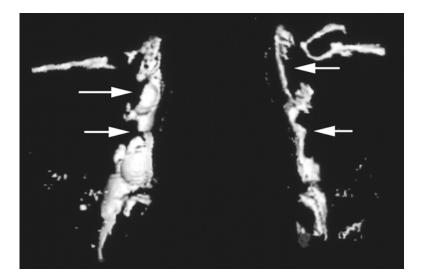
CT-DCG three-dimensional reconstruction in the left oblique projection confirms the left complete obstruction and proximal dilation. Right system is normal (Courtesy of Susan K. Freitag, M.D., reprinted with permission from Lippincott, Williams & Wilkins ©2002)
